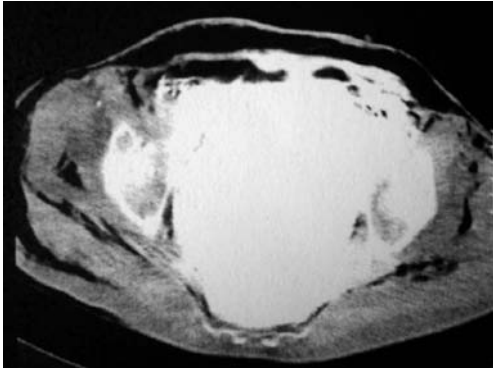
CT showed perirectal migration of barium in pelvic cavity and subcutaneous emphysema.
